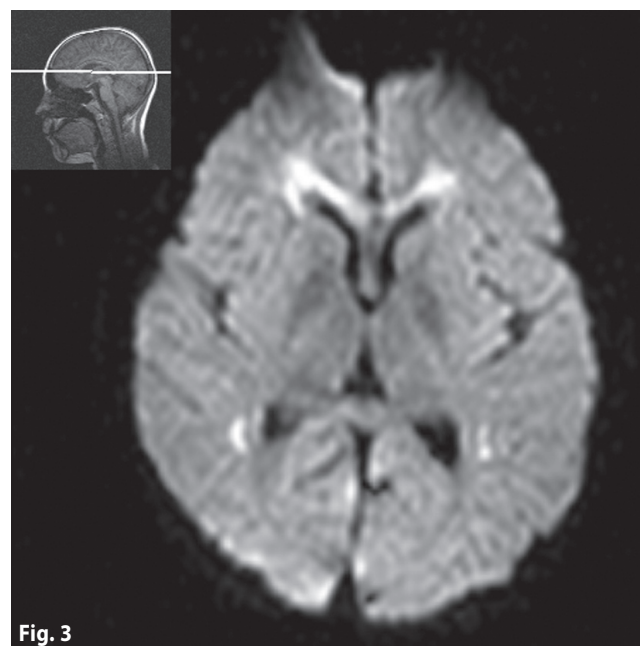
Transverse FLAIR. Increased signal intensity on FLAIR sequence in the areas of white matter, periventricularly located.
